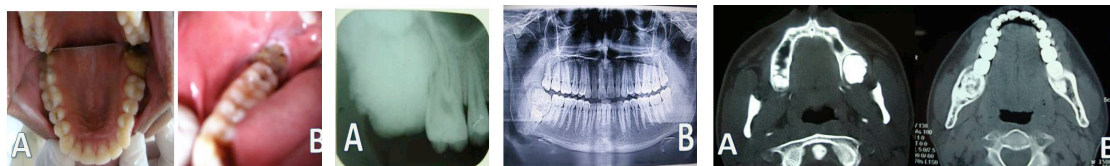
Clinical Presentation of opaque lesion in Case; 1B: Clinical Presentation of opaque lesion in Case 2; Figure-2A: Case 1- IOPA showed large, irregular, well defined radiopaque mass; 2B: Case 2- Panoramic radiograph revealing irregular globular like radiopaque lesion; Figure-3A & B: CT scan of Case 1 and 2 showing the opaque lesion causing expansion of both the buccal and lingual alveolar plates.
